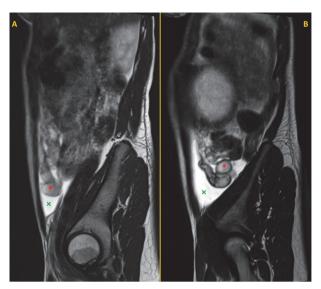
Sagittal T2-weighted magnetic resonance images showing the right (A) and left (B) Fallopian tubes (red asterisks), dilated and filled with a hyperintense content as well as intraperitoneal free fluid (green crosses) compatible with bilateral hematosalpinx.
